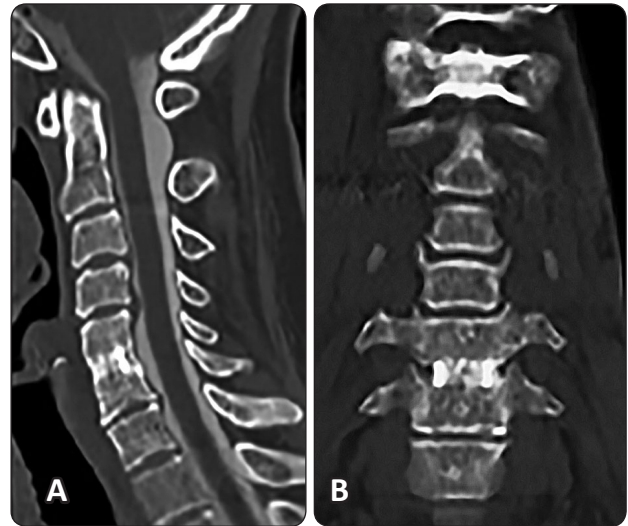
(A) Sagittal and (B) Coronal multislice CT reconstruction of the cervical spine showing complete fusion of the operated cervical segment (C5-C6)
